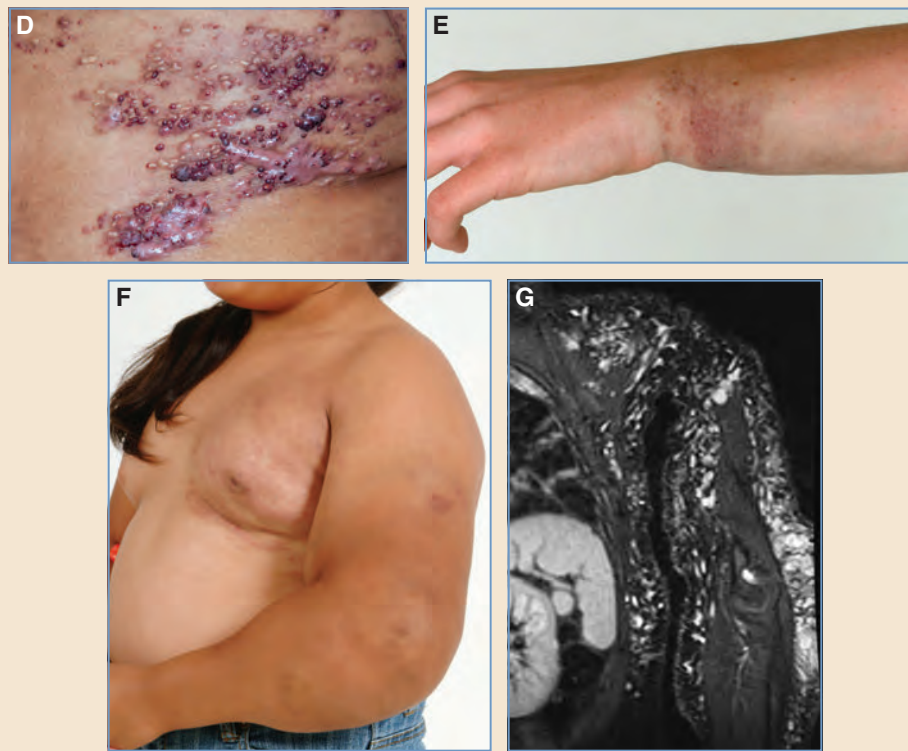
cont'd D, Microcystic lymphatic malformation of the skin (sometimes referred to as *lymphangioma circumscriptum*) with recurrent bleeding from skin lesions. E, Firm, noncompressible expansion of the wrist with bruising (from spontaneous intralesional hemorrhage) in a microcystic lymphatic malformation (the same patient is shown in ultrasonography scan in Fig. 13-6, *B*, and in MRI scan in Fig. 13-7, *D-F*). F and G, Extensive subcutaneous microcystic lymphatic malformation in the upper extremity, shoulder, and chest wall.
